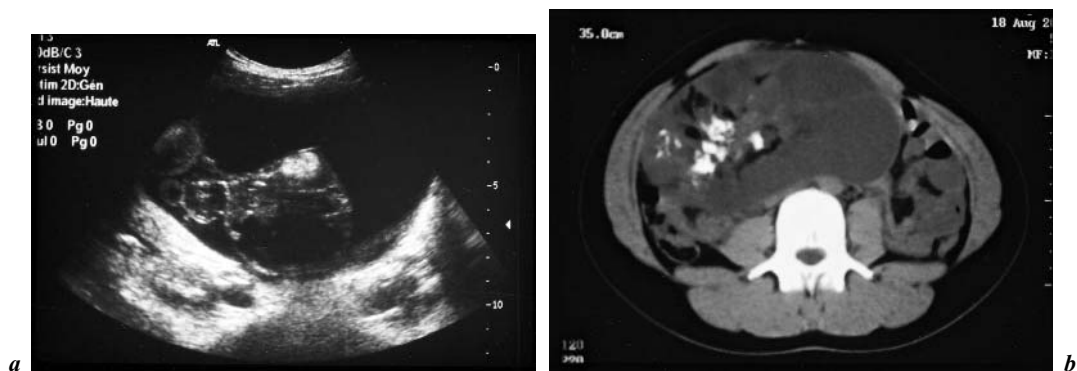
Dermoid cyst. a Ultrasonography. Heterogeneous mass, predominantly fluid, with a tissue component and echogenic calcifications. b CT scan. Heterogeneous, multilocular, calcified mass, with a highly suggestive fat content.
